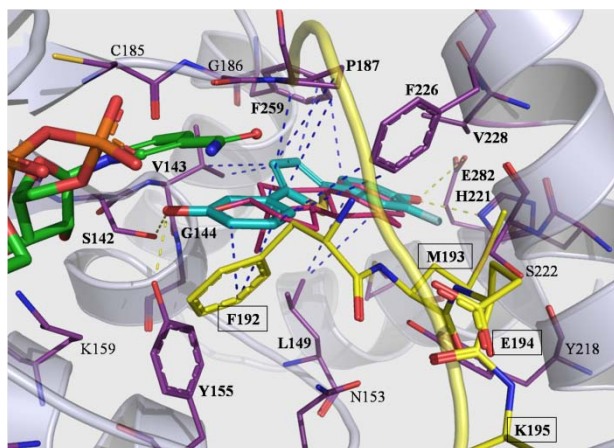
Docking complex between 17 β -HSD1 (X-ray 1FDT-B) and compound 23 (blue; SUB binding mode). NADPH, interacting residues and ribbon rendered tertiary structure of the active site are shown. Residues of the flexible loop are rendered in sticks and colored in yellow. Hydrogen bonds and π - π stackings (and hydrophobic interactions) are drawn in yellow and blue dashed lines, respectively. For comparison, E2 is depicted in magenta lines. Figures were generated with Pymol (<http://www.pymol.org>).
